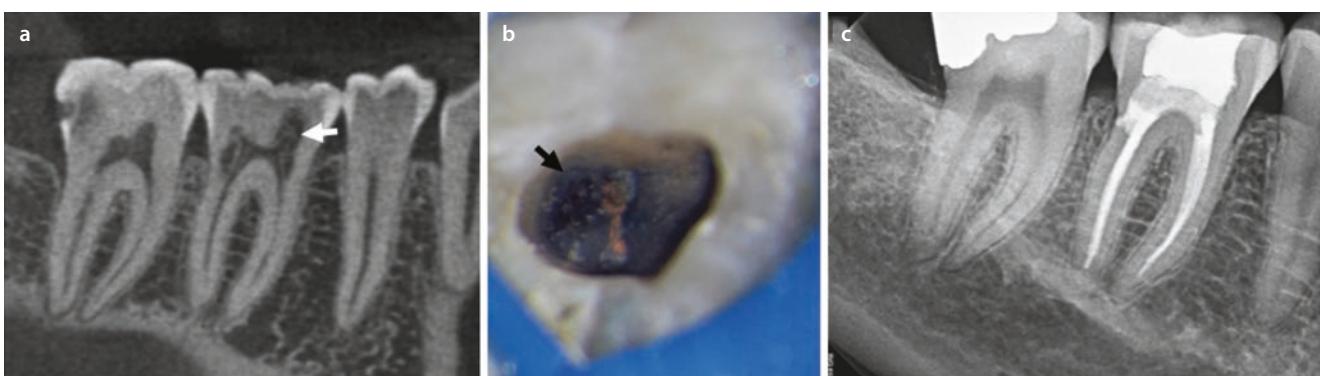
CBCT coronal a orthogonal plane shows Class 3 ICR on tooth #30 with presence of intact pre-dentin layer (white arrow). Endodontic therapy was completed, then perforated defect in distal
